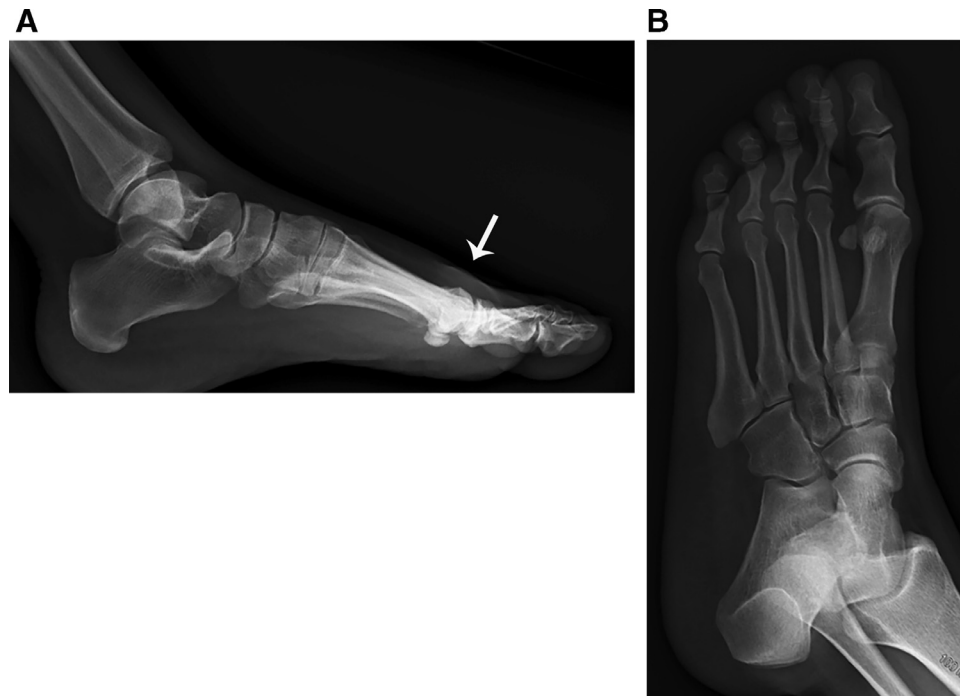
(a,b) Lateral and oblique radiographs of the left foot during prior visit (2 years before current encounter) show an area of nonspecific swelling and increased soft tissue density overlying the third and fourth metatarsal heads. There is no soft tissue calcification, osseous erosion, or periosteal reaction.
